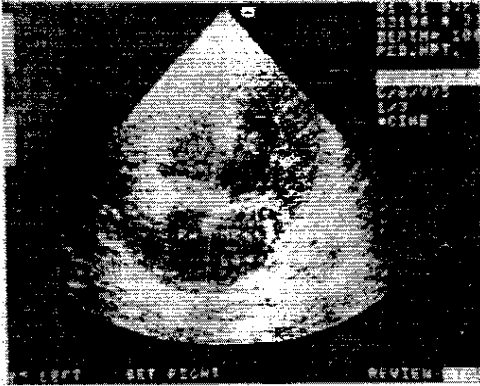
Colour flow Doppler showing mitral regurgite in a patient with mucopolysaccharidosis type I
